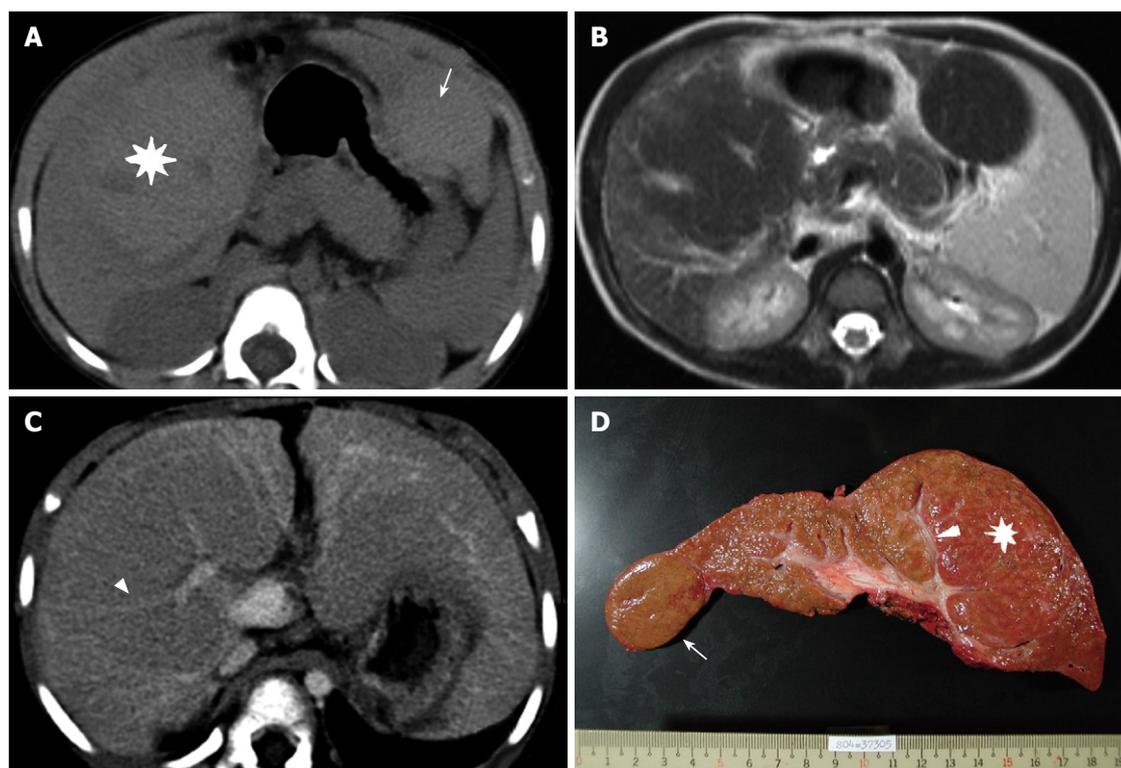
A 3-year-old BA girl with segments 5-8 (asterisk) and segment 2 (arrow) MRN. A: The density of the MRN is slightly higher than that in the surrounding liver parenchyma during pre-enhanced phase of the CT; B: FSE/T2WI MRI shows a lower signal intensity in the MRN than in the surrounding liver; C: During portovenous phase of the CT, the tubular structure and splaying portal veins can be seen in the MRN (arrowhead); D: The explanted liver and intra-tumoral portal tract can be seen (arrowhead).
